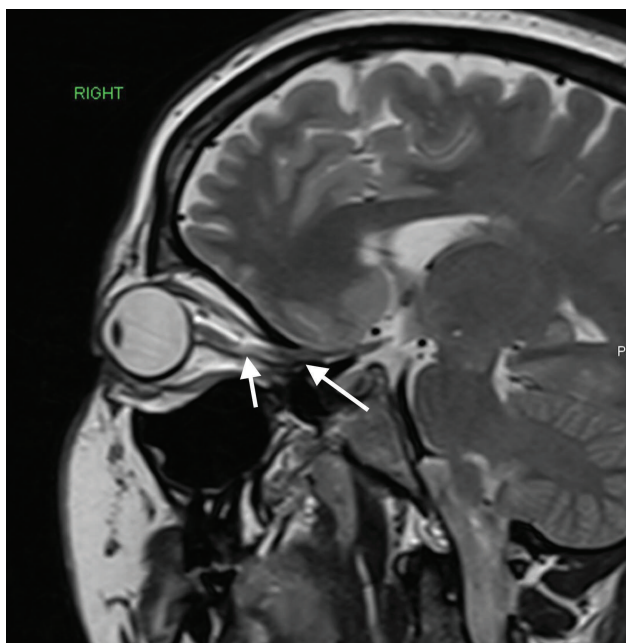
Magnetic resonance imaging brain showing mild tortuosity of optic nerve.
